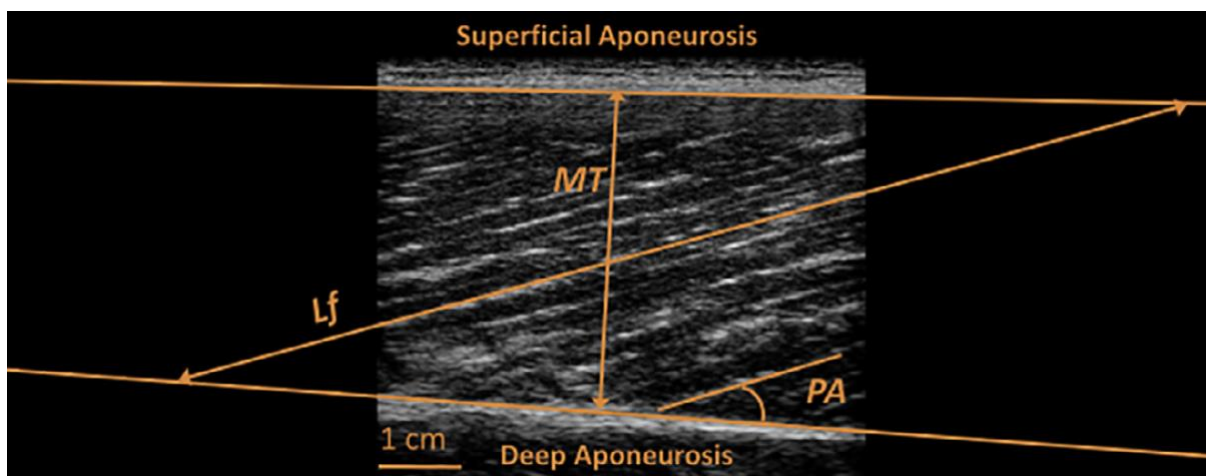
Longitudinal ultrasound image showing vastus lateralis muscle architecture.* Horizontal orange lines denote extended upper and lower aponeurosis for fascicle length (Lf) extrapolation. Pennation angle (PA) is shown as the fascicle angle orientated with the deep aponeurosis. Muscle thickness (MT) is also shown for reference (adapted from Franchi et al, 2018).
